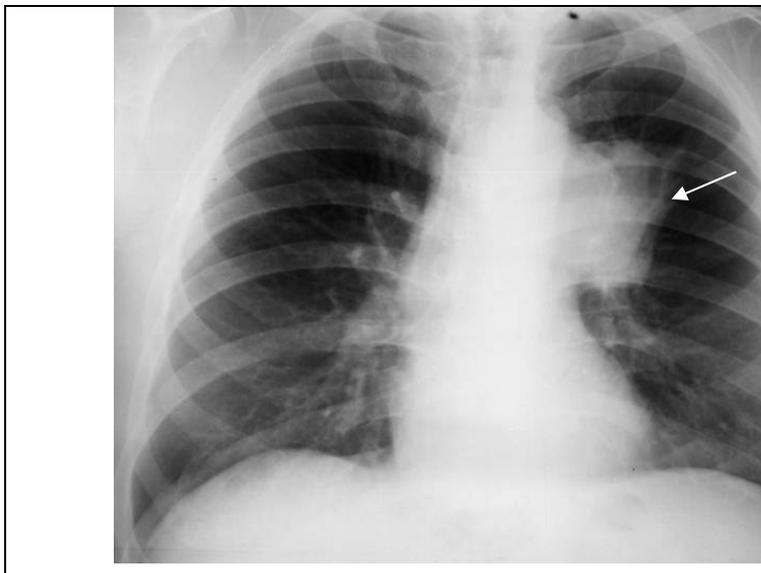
The frontal chest radiograph.
